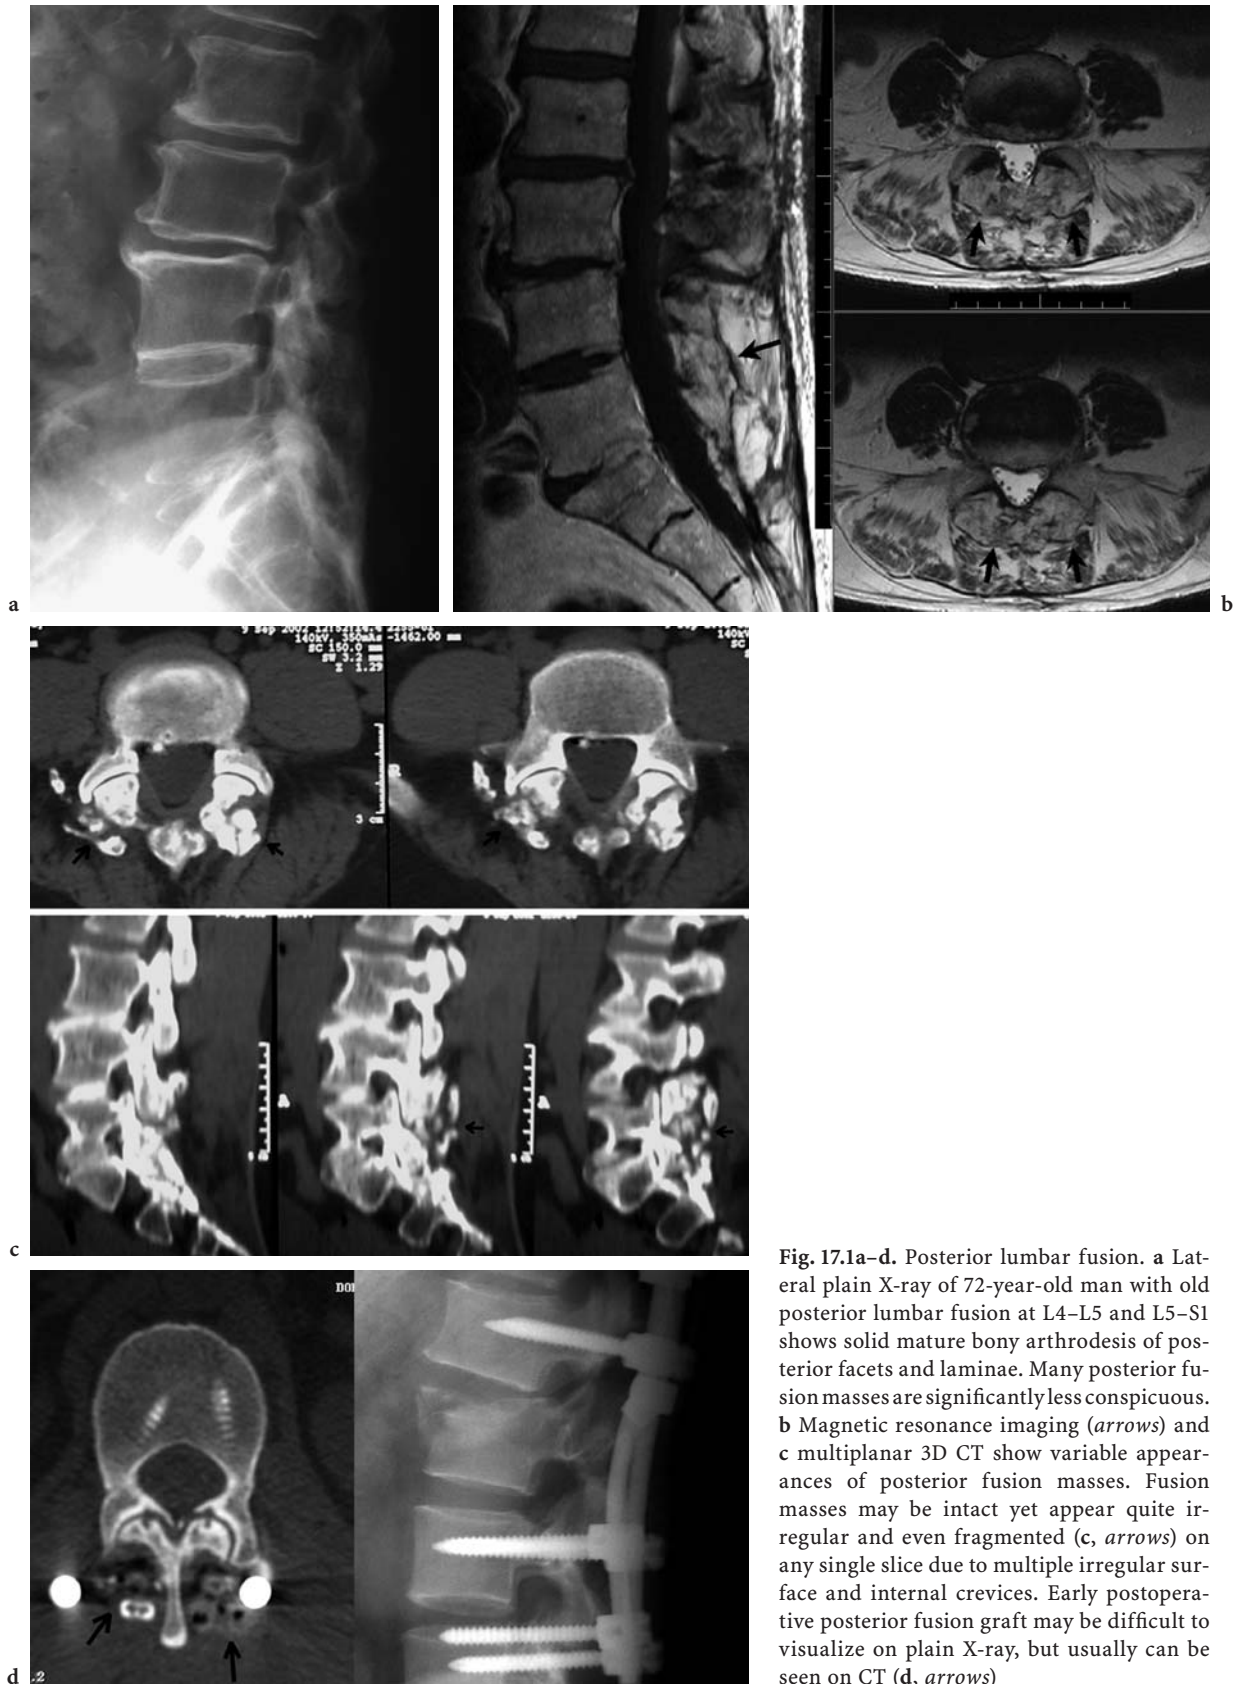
Posterior lumbar fusion. a Lateral plain X-ray of 72-year-old man with old posterior lumbar fusion at L4–L5 and L5–S1 shows solid mature bony arthrodesis of posterior facets and laminae. Many posterior fusion masses are significantly less conspicuous. b Magnetic resonance imaging (*arrows*) and c multiplanar 3D CT show variable appearances of posterior fusion masses. Fusion masses may be intact yet appear quite irregular and even fragmented (c, *arrows*) on any single slice due to multiple irregular surface and internal crevices. Early postoperative posterior fusion graft may be difficult to visualize on plain X-ray, but usually can be seen on CT (d, *arrows*)
